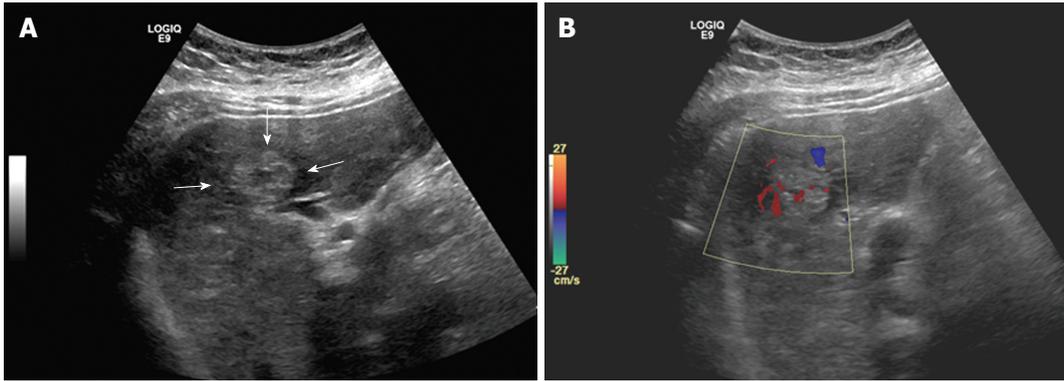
Ultrasonographic findings of hepatic angiosarcoma. A: Representative image of tumor detected by abdominal ultrasound (arrow). Note the increased peripheral echogenicity and hypoechoic central appearance; B: Color doppler study of (A) demonstrates hypervascularity of the tumor. No arterial flow was detected (image not shown).
